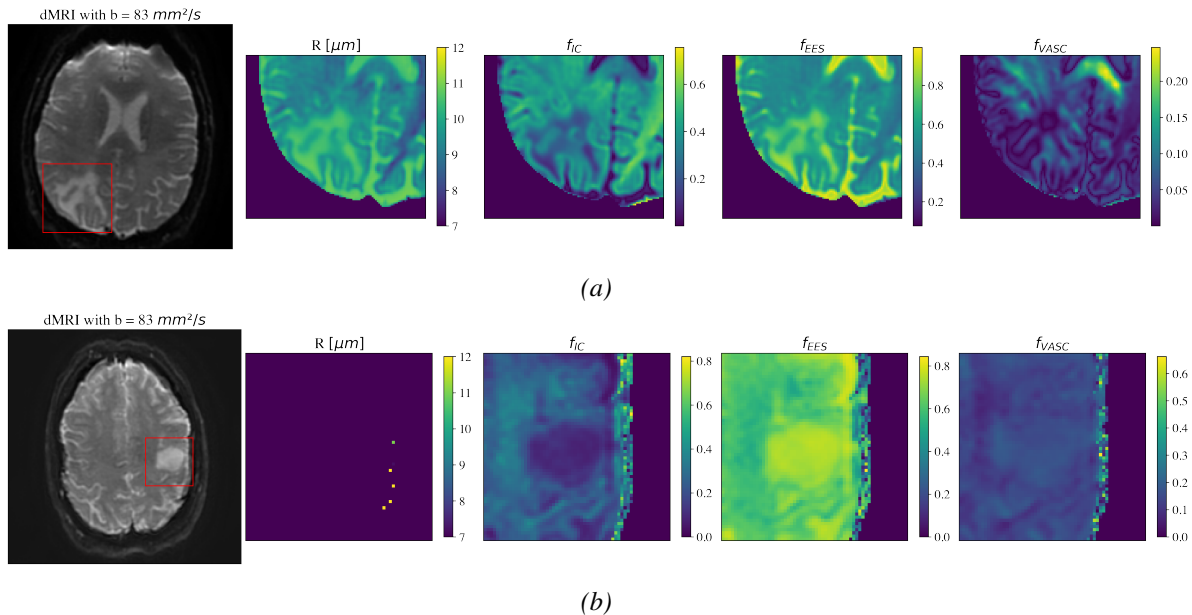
in vivo* diffusion MRI with VERDICT parameter predictions. The ROI is highlighted in two dMRI scans, and parameter predictions are shown for the corresponding region. The parameters include the radius and three volume fractions: intracellular (f_{IC}), extracellular-extravascular (f_{EES}) and vascular (f_{VASC}) in an MRI protocol consisting of 160 gradient combinations.
